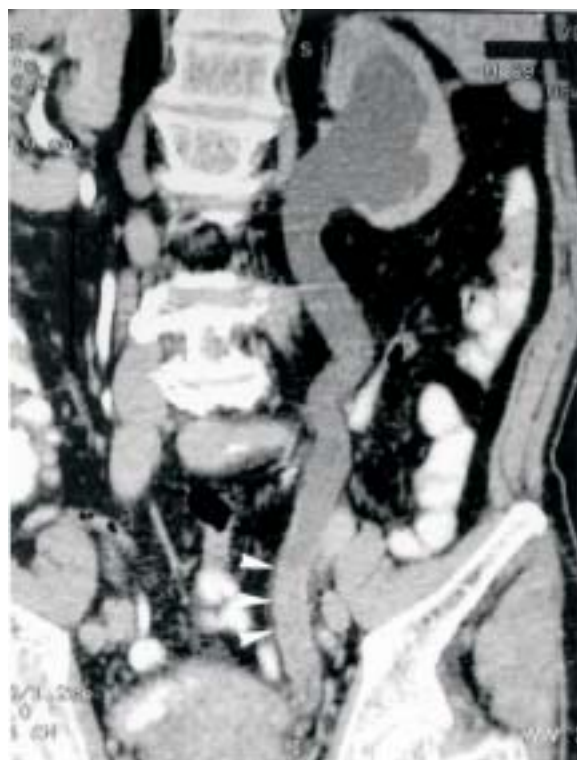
A 69-year-old man with gross hematuria for 1 month. CT urography shows marked left hydronephrosis and hydroureter. Note increased soft tissue density of the left distal ureter (arrowheads) which causes obstruction uropathy. Urothelial cell tumor of the left distal ureter was impressed, and was proved by surgery.
